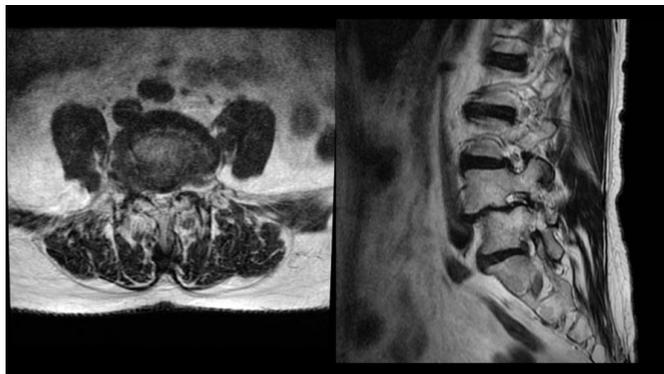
MRI showing Grade II listhesis with L4-L5 right foraminal stenosis.
